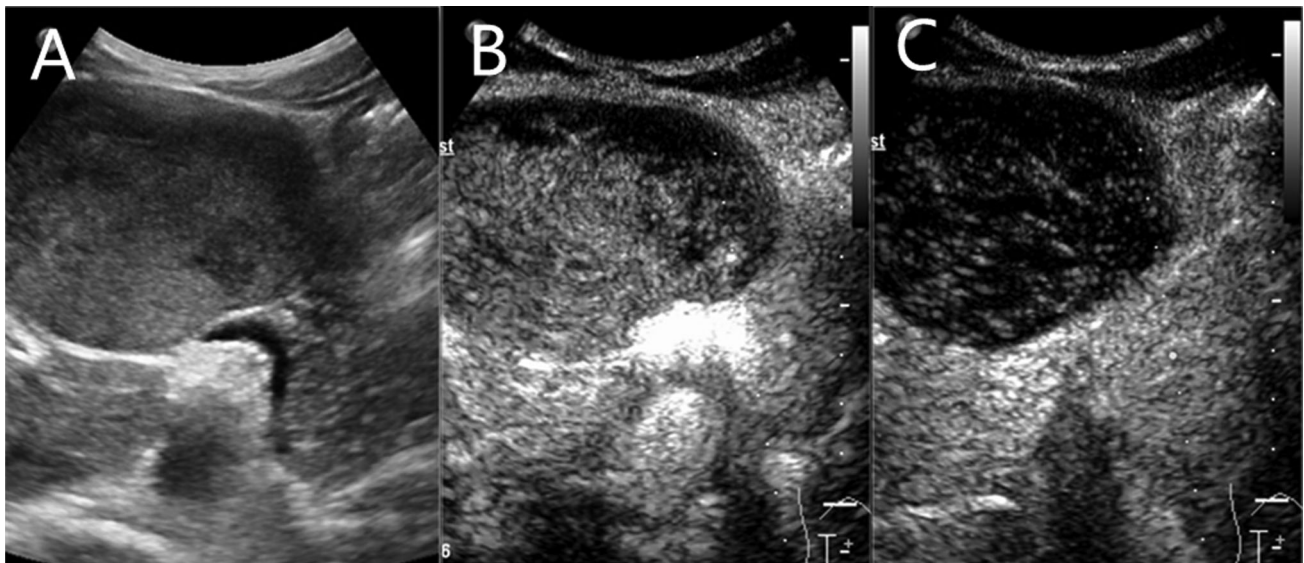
A slightly weaker echogenic mass on ultrasound. (A) Two-dimensional ultrasonography. (B) contrast-enhanced ultrasound (CEUS) in arterial phase. (C) CEUS in parenchymal phase.
